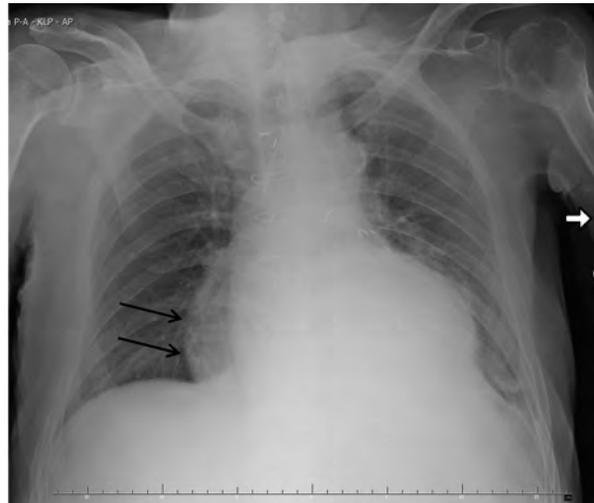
Posterior–anterior chest X-ray. A large diaphragmatic hernia is visible at the base of the lung (black arrows) with a diameter of 21 cm
